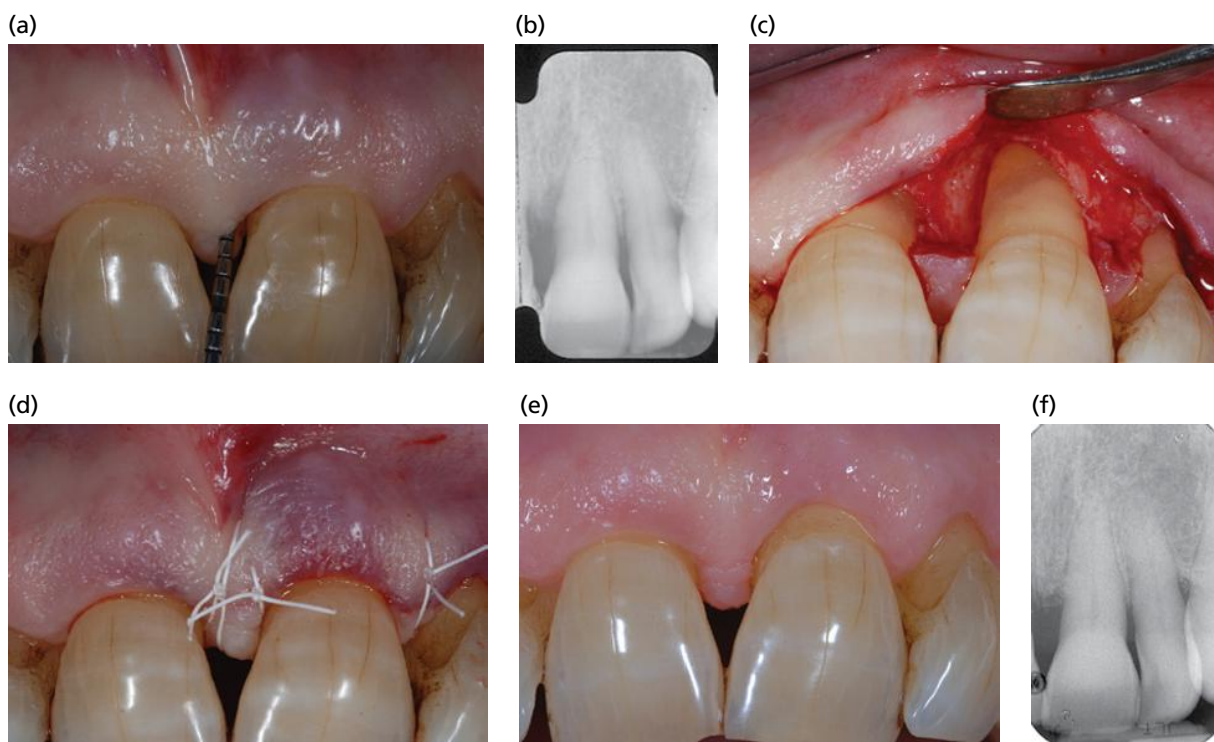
Clinical case treated with the modified minimally invasive procedure (M-MIST). A 10-mm pocket mesial to the upper right cuspid (a) was associated with a deep intrabony defect reaching the mid third of the root (b). Area was accessed with the M-MIST procedure (c). Buccal flap was minimally elevated to the mid-buccal contour of the cuspid and the lateral incisor. The defect-associated interdental papilla was left untouched and the lingual flap was not elevated. The intrabony defect and the exposed root surface were instrumented through the small buccal surgical “window”. A single modified internal mattress suture was positioned to close the area (d). No regenerative material was placed into the defect, leaving the natural blood clot alone to fill the intrabony component. Integrity of the primary closure of the wound was maintained after 1 week (e). One-year clinical photograph showed a 3-mm normal sulcus, associated with a 7-mm clinical attachment gain and no increase in gingival recession (f). One-year radiograph showed the complete resolution of the intrabony component of the defect (g).
